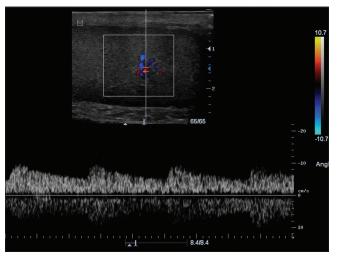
Color Doppler ultrasound demonstrates venous flow in draining vein of the lesion
